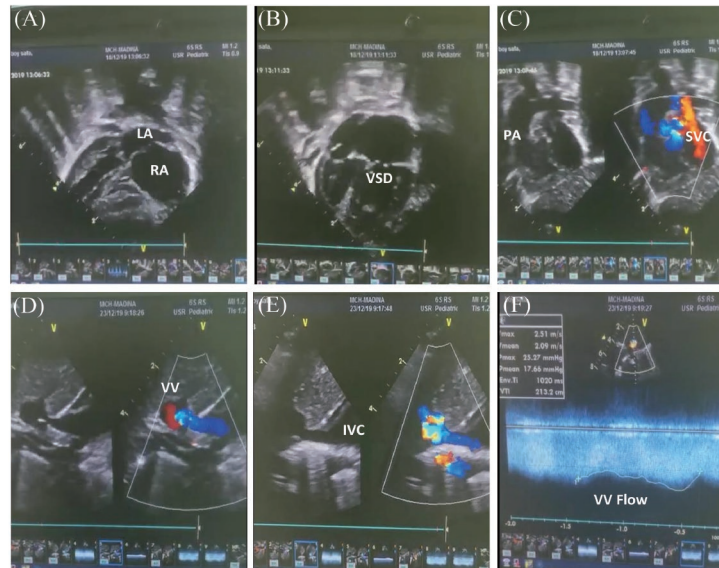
Echocardiography imaging of the neonate with obstructed infracardiac type total anomalous pulmonary venous connection (TAPVC) revealed (A) Mirror-image dextrocardia, dilated RA, ASD, and small-sized LA with no attached pulmonary veins. (B) Large inlet to outlet VSD. (C) Bilateral SVC attached to RA, and single VV going downward behind the heart. (D) VV tracked down to the IVC. (E) Turbulence at site of entry of VV into IVC. (F) Doppler of VV flow. RA, right atrium; LA, left atrium; ASD, atrial septal defect; VSD, ventricular septal defect; SVC, superior vena cava; IVC, inferior vena cava; VV, vertical vein.
